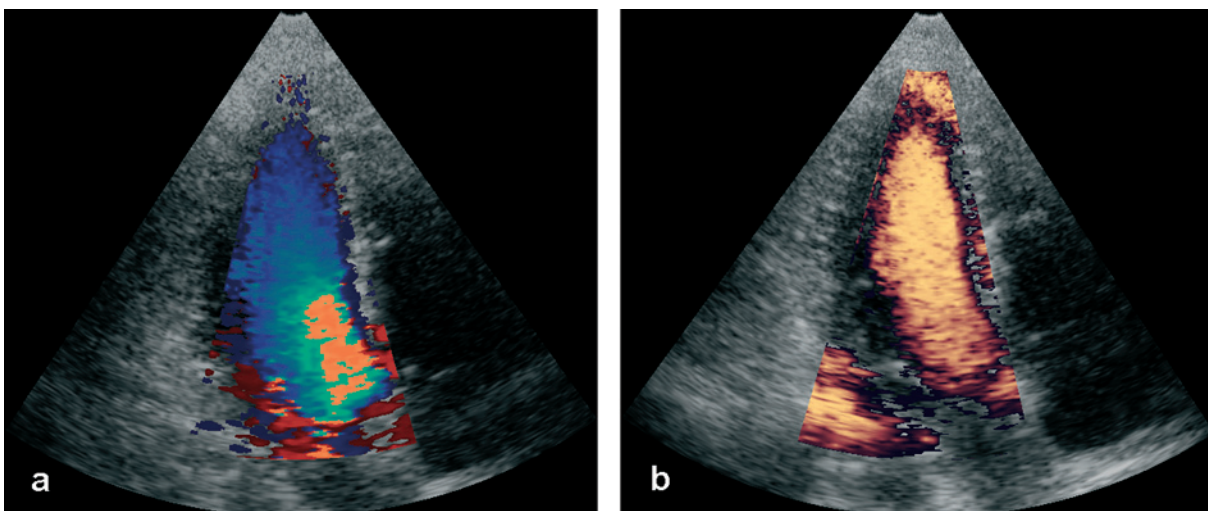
Doppler images produced by an ATL 5000 scanner, (a) a Colour Velocity Doppler image of blood flow in the left ventricle, (b) a Power Doppler image of blood flow in the left ventricle.
